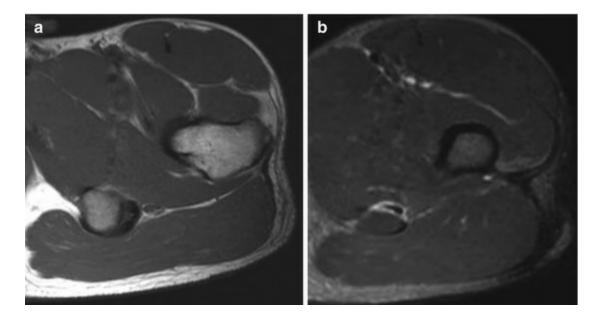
A 21-year-old male soccer player with proximal tendinopathy of the semimembranosus. Axial T1-weighted MRI (a) shows subtle areas of increased intratendinous signal intensity and axial STIR image (b) shows edema
